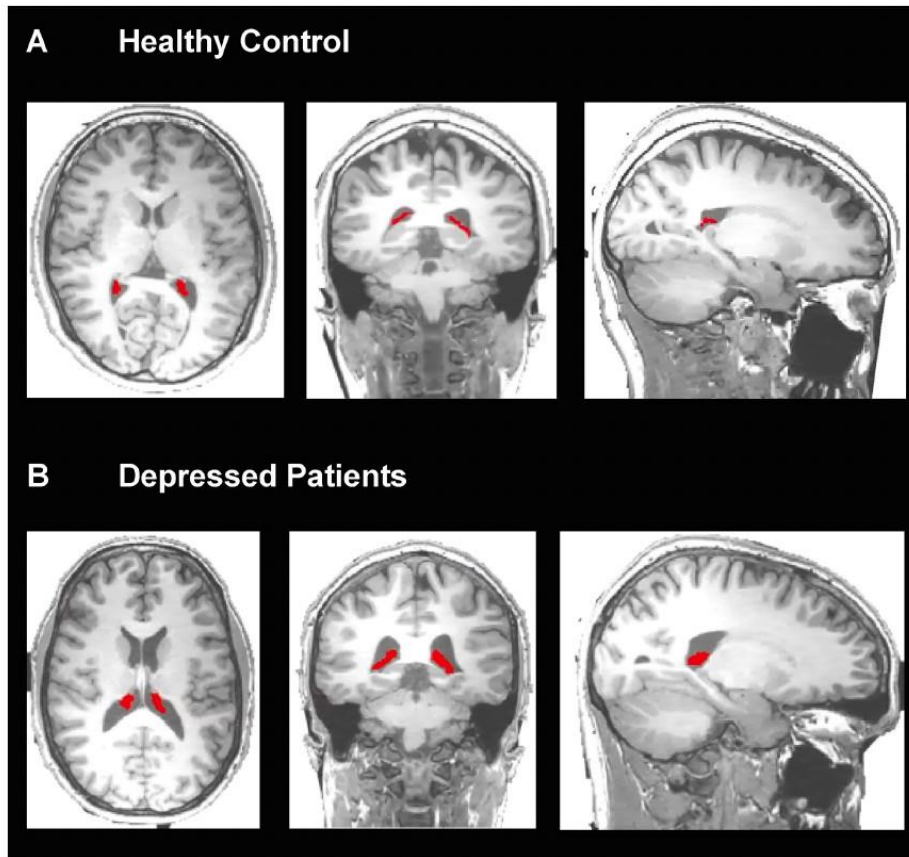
Choroid plexus (CP) segmentation in HCs and depressed subject. T1-weighted MRI images with the manual segmentation of the left and right CP (red) on the axial, coronal, and sagittal planes for one representative control (A) and one depressed subject (B). (For interpretation of the references to colour in this figure legend, the reader is referred to the web version of this article.)
